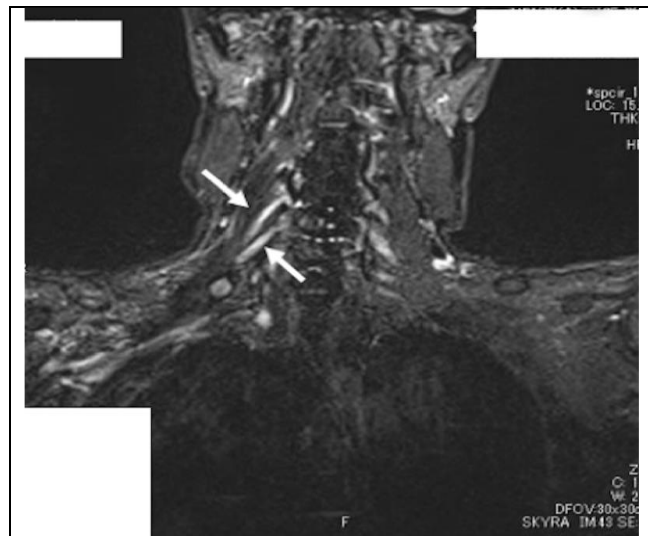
MRI scan on STIR sequence: White arrows show the injury to the right C5 and C6 nerve roots. STIR, short TI inversion recovery
